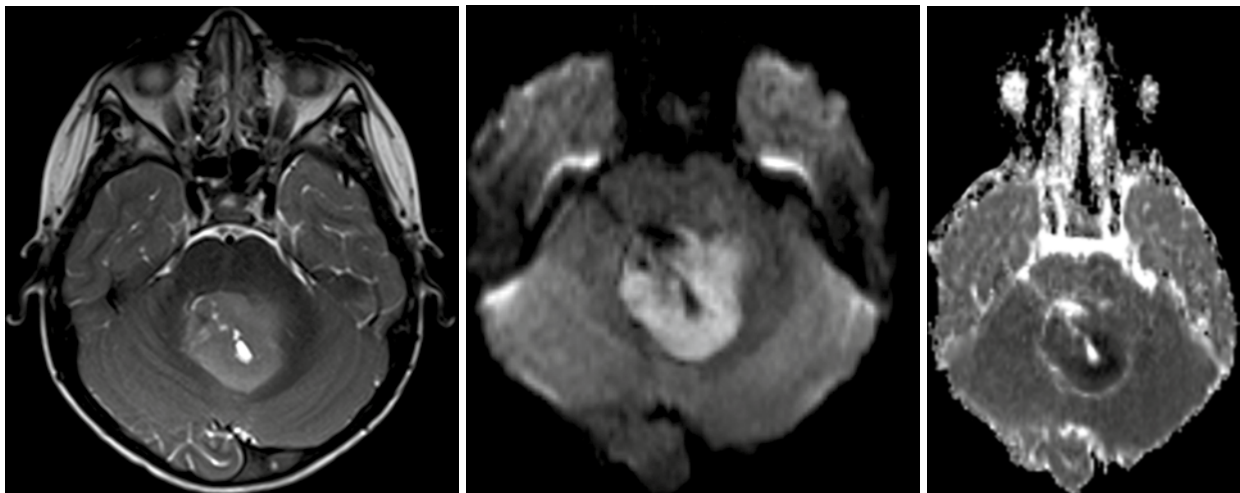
Typical medulloblastoma of the 4th ventricle with slightly hyperintense T2w signal, strongly elevated DWI signal and very low ADC values in the solid tumor parts (from left to right)
